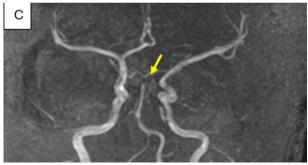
Computed tomography scan with injection showing pearled appearance at the origin of the right posterior cerebral artery (red arrows) (A, B) and short stenosis at basal trunk termination (MRI angiographic sequence yellow arrow) (C)
